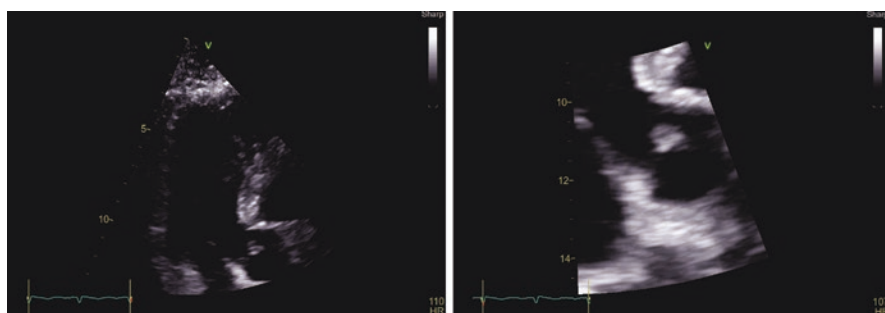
Echocardiography of the patient with endocarditis of aortic valve
